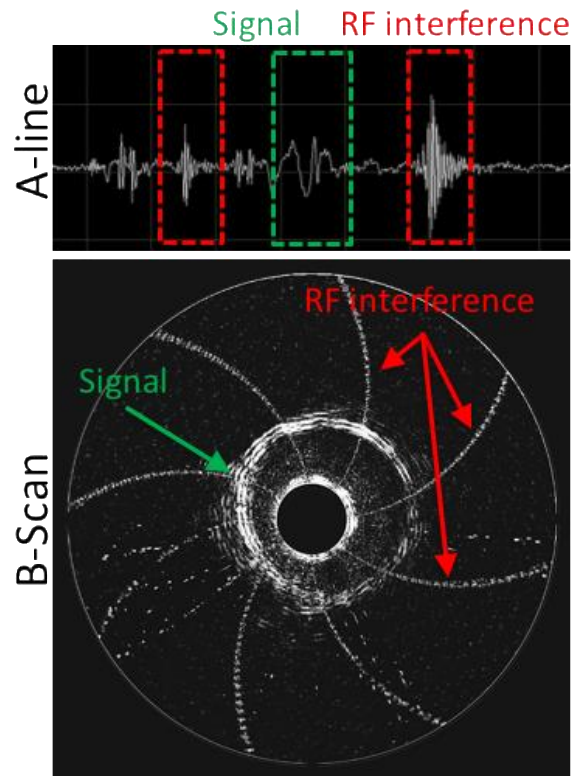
Effect of parasitic RF interference on an ultrasound image.
